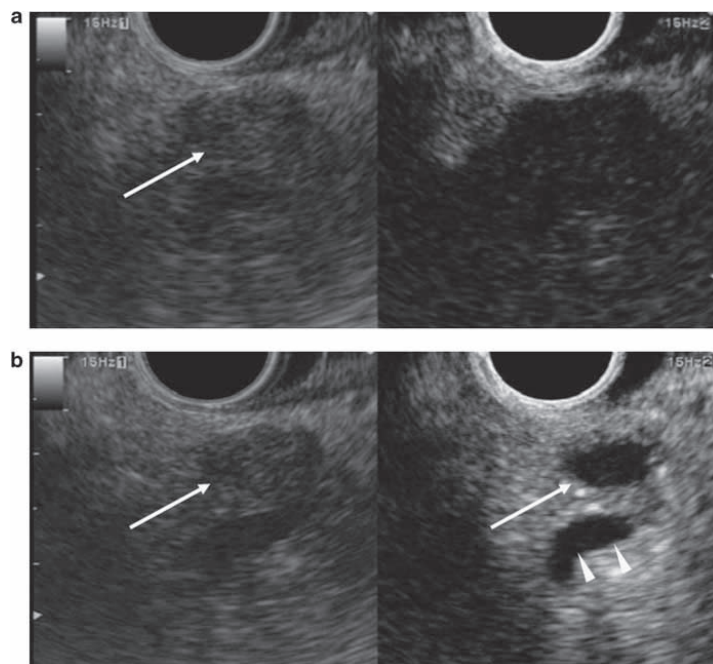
A typical example of a solid lesion with nonenhancement (in this case, an inflammatory pseudotumor). (a) Images before infusion of the ultrasound contrast. Conventional endoscopic ultrasonography (EUS; left) reveals a slightly hypoechoic area (arrow) at the pancreas head whereas the specific mode for contrast harmonic imaging (right) cannot depict either the pancreatic parenchyma or the area very clearly. (b) Images 30 s after infusion of the ultrasound contrast. Although the conventional EUS images (left) do not change over time, contrast-enhanced harmonic endoscopic ultrasonography (CH-EUS; right) shows parenchymal perfusion imaging in the pancreas, and indicates that this area (arrow) has nonenhancement and a clear margin relative to the surrounding tissue. CH-EUS also shows the pancreatic duct as an avascular structure (arrowheads).
